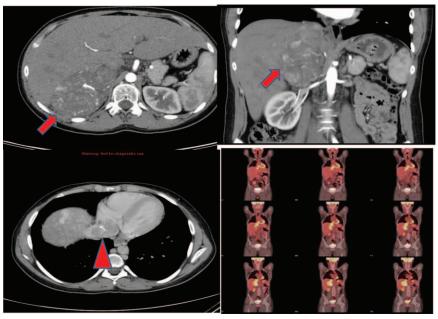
Axial and coronal cuts of a contrast-enhancing CT scan of the abdomen and chest showing a large heterogeneous mass (arrows) extending from the right adrenal region through the IVC behind the liver and reaching the right atrium (arrowhead) showing a mass of 10.9 × 8.1 × 9.2 cm. Serial cuts of 18-flurodeeoxyglucose PET/CT scans (right lower panel) are showing an intense uptake and extension of the same mass seen on CT scan. CT = computed tomography, IVC = inferior vena cava, PET = positron emission tomography.
